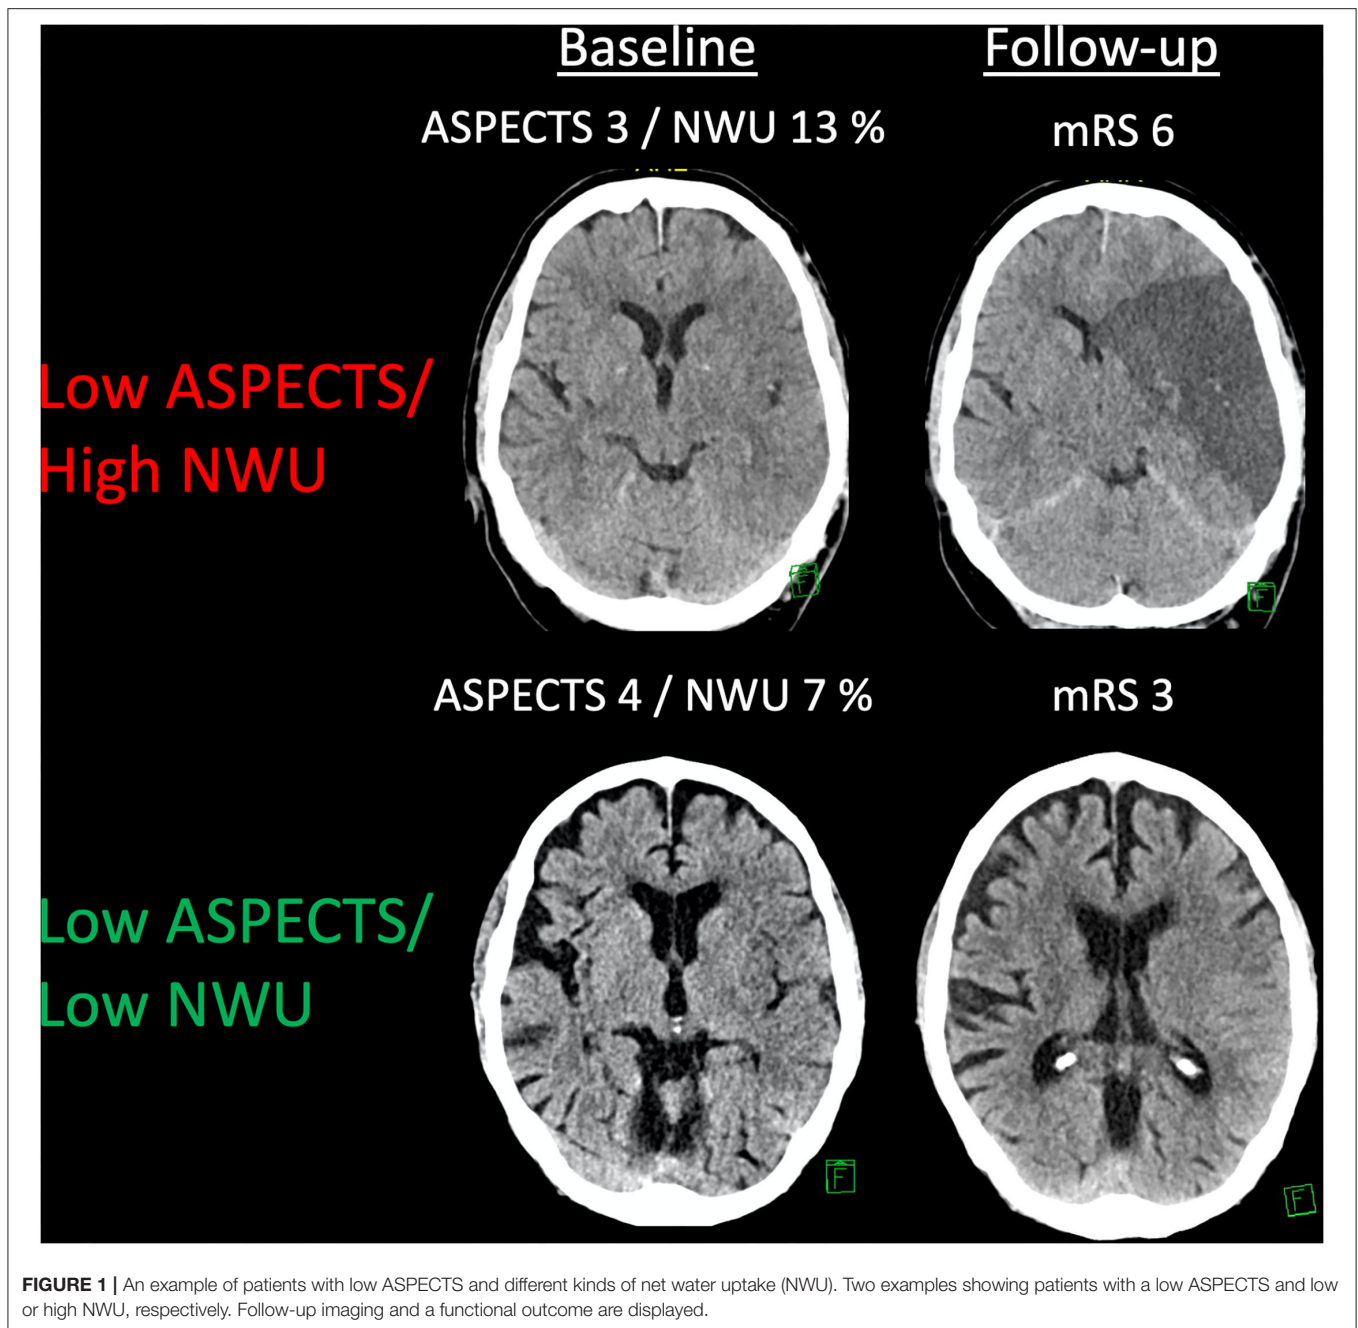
An example of patients with low ASPECTS and different kinds of net water uptake (NWU). Two examples showing patients with a low ASPECTS and low or high NWU, respectively. Follow-up imaging and a functional outcome are displayed.
